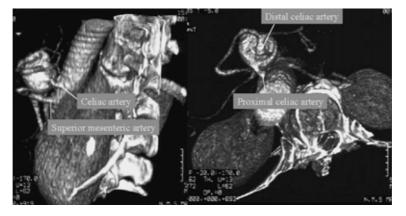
Three-dimensional computed tomographic angiogram localized the celiac artery aneurysm to the mid portion of the celiac artery.
